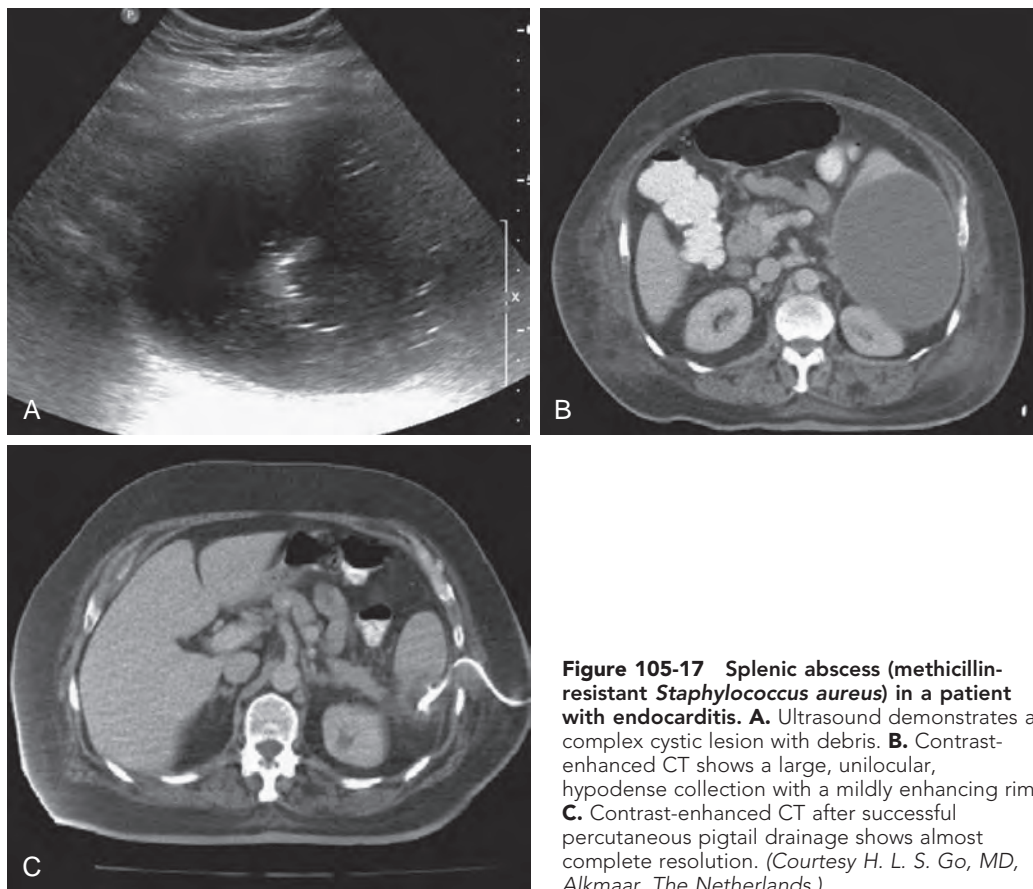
Splenic abscess (methicillin-resistant *Staphylococcus aureus*) in a patient with endocarditis. A. Ultrasound demonstrates a complex cystic lesion with debris. B. Contrast-enhanced CT shows a large, unilocular, hypodense collection with a mildly enhancing rim. C. Contrast-enhanced CT after successful percutaneous pigtail drainage shows almost complete resolution. (Courtesy H. L. S. Go, MD, Alkmaar, The Netherlands.)
